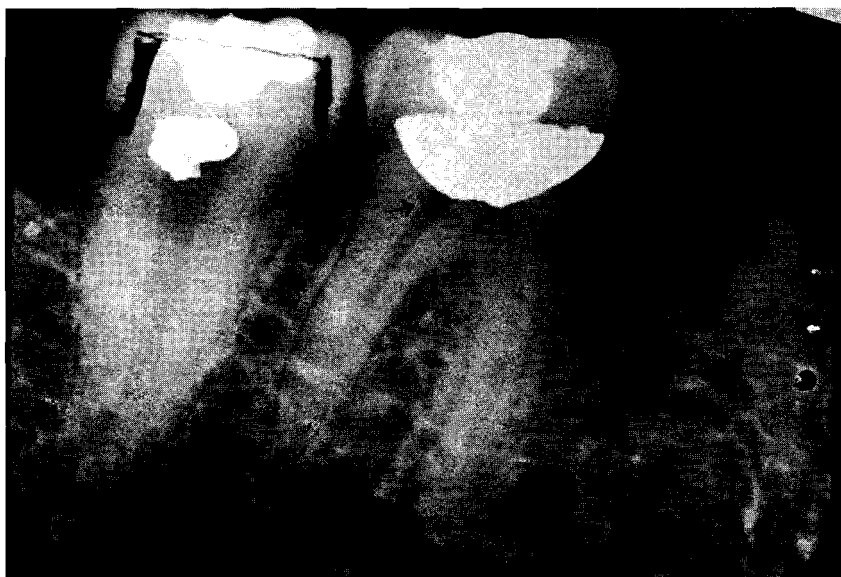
Radiograph eleven months after placement of gold foil restoration (arrows indicate site of resorption)
